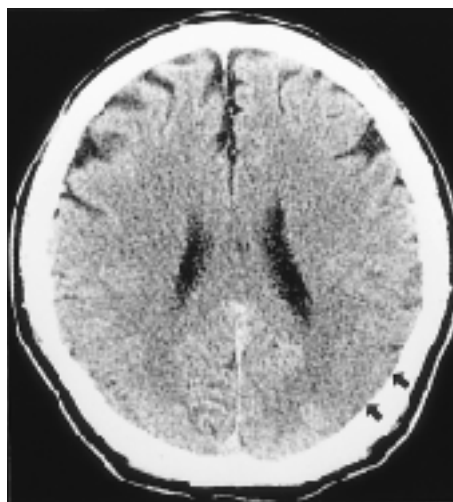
A 78 year-old man with right hemiplegia and altered mentality. (A) Axial unenhanced CT scan obtained within two and a half hours of symptom onset reveals subtle hypoattenuation with loss of gray-white matter interface in the left frontoparietal region(short arrows). Also note low attenuation lesions of chronic infarction in the bilateral deep periventricular white matter(long arrows). Axial T2-weighted MR (B) and axial fast FLAIR MR (C) images obtained two hours after CT scan show no definite increased signal intensity in the left frontoparietal region. The deep periventricular white matter lesions show high signal intensity(arrows). (D) Diffusion-weighted MR image demonstrates high signal intensity lesion in the left frontoparietal region(arrows).
